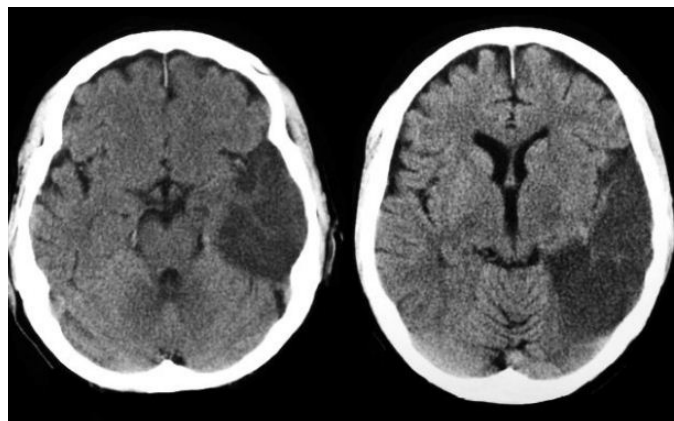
CT Brain image of MCA territory infarct
